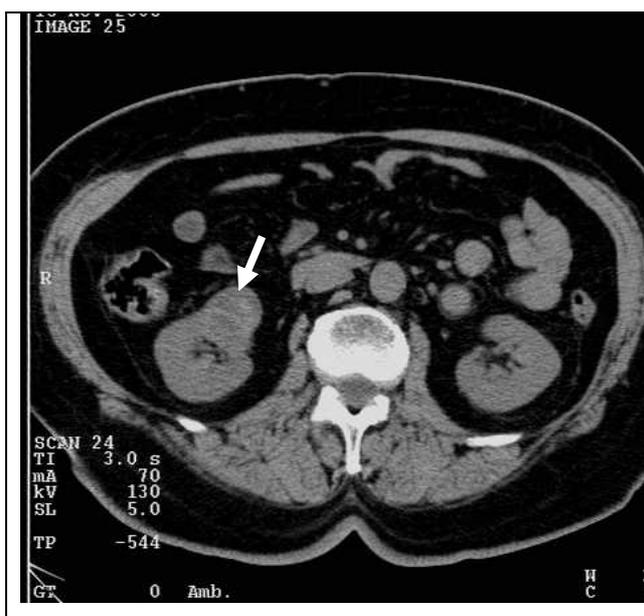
CT-imaging. Computer tomogram of an abdomen cavity at level L2 vertebrae. The right kidney is enlarged, its contours rough (arrow). Renal cell carcinoma.
